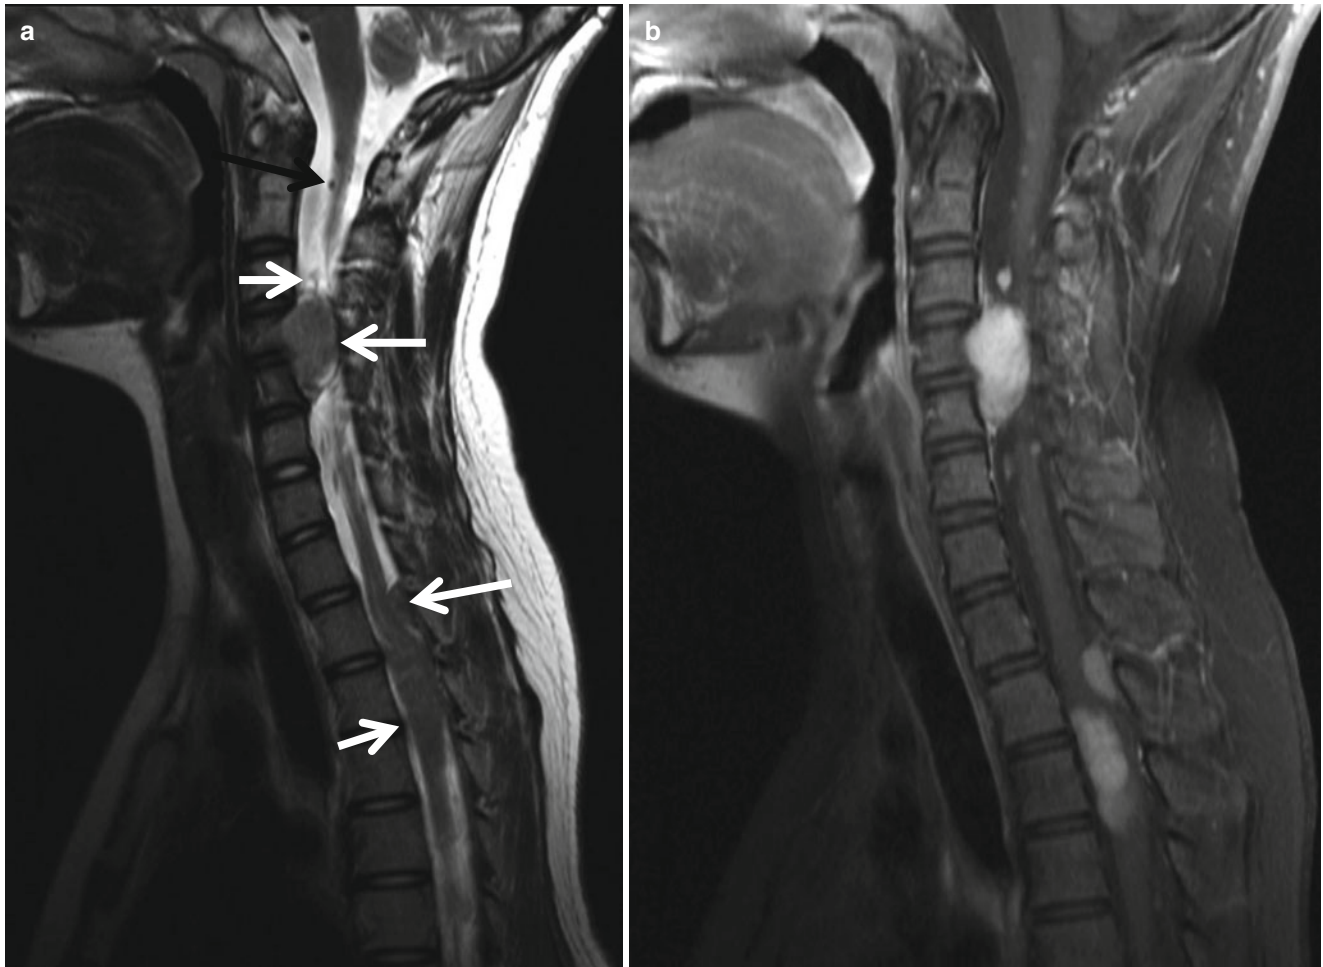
Multiple schwannomas in a patient with type 2 neurofibromatosis. (a) T2-weighted sagittal image shows multiple IDEM masses of isointensity (*arrows*). The masses are scalloping the posterior surface
